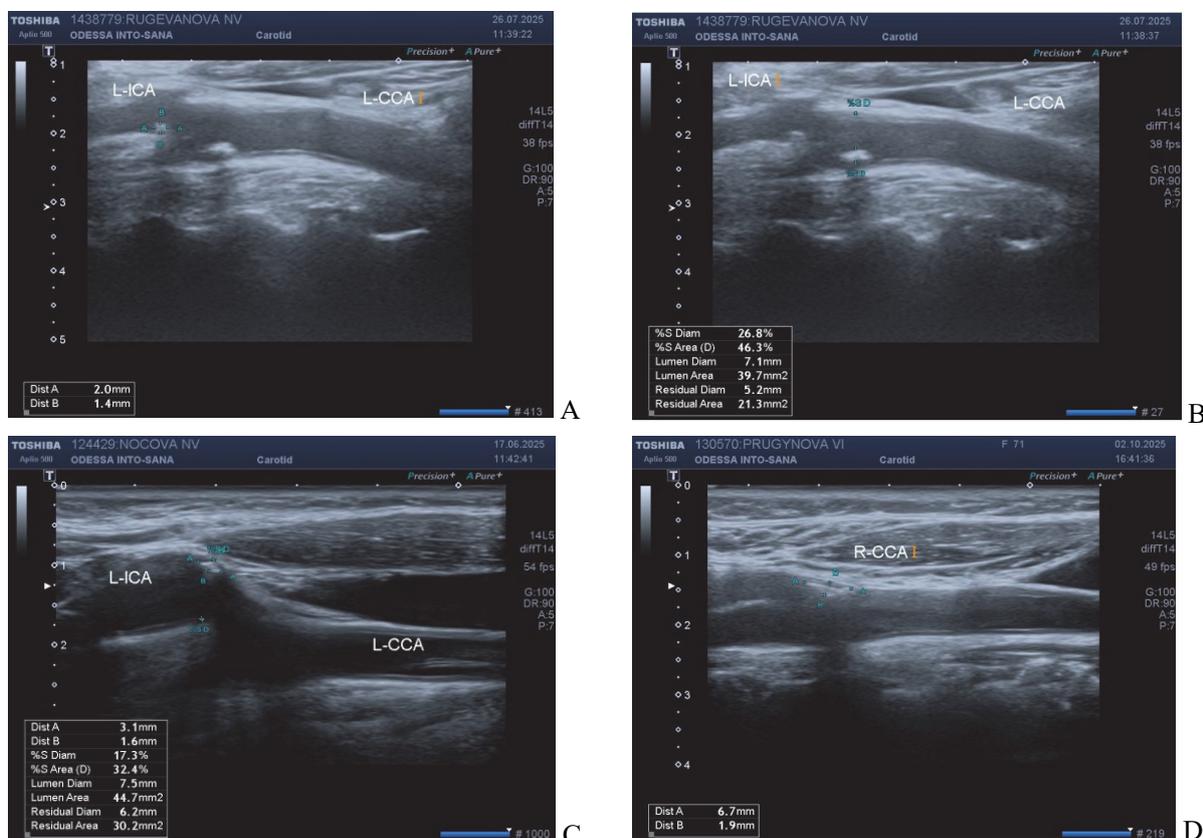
Examples of B-mode ultrasonographic images of patients with atherosclerotic changes in the brachiocephalic arteries. A – Echogram of a patient with two atherosclerotic plaques in the CCA and ICA; B – Measurement of plaque size and degree of stenosis (measured by diameter in longitudinal section, ECST method); C – Hyperechoic atherosclerotic plaque along the anterior wall of the left ICA; D – Calcified atherosclerotic plaque with acoustic shadowing located at the bifurcation of the CCA.
